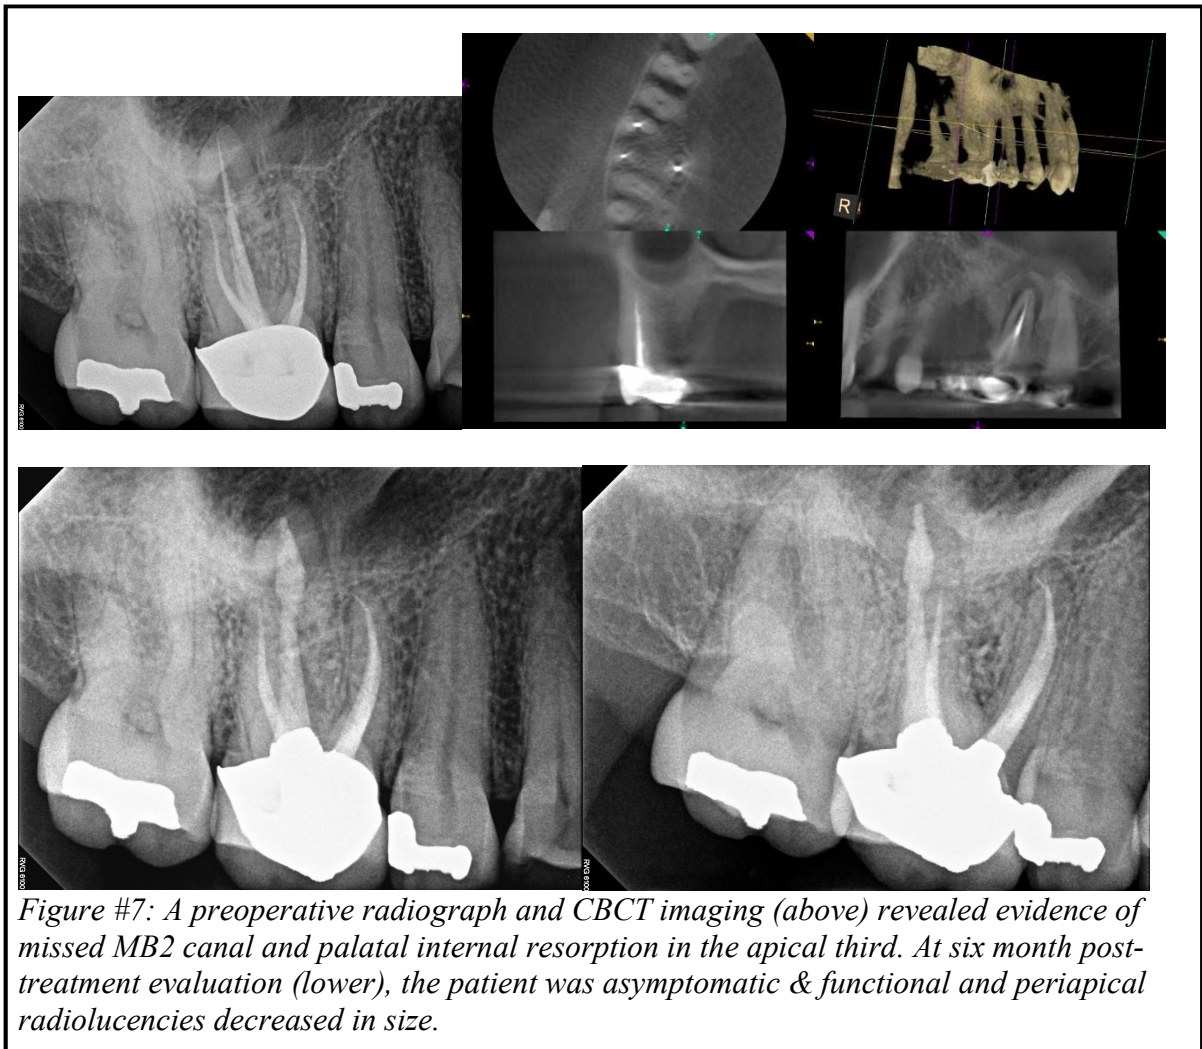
Figure #7: A preoperative radiograph and CBCT imaging (above) revealed evidence of missed MB2 canal and palatal internal resorption in the apical third. At six month post-treatment evaluation (lower), the patient was asymptomatic & functional and periapical radiolucencies decreased in size.
